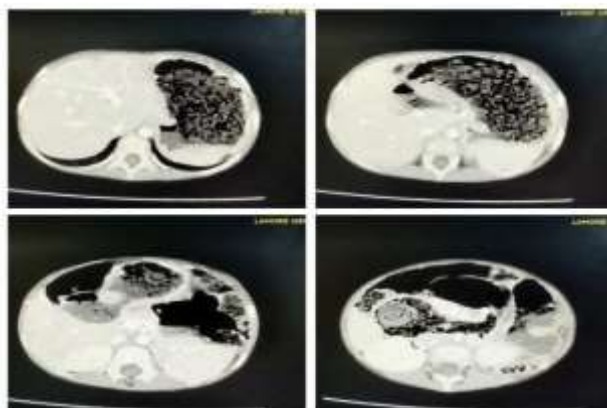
Computed tomography views: soft-tissue densities compatible with a bezoar in the stomach extending throughout the small intestine.
